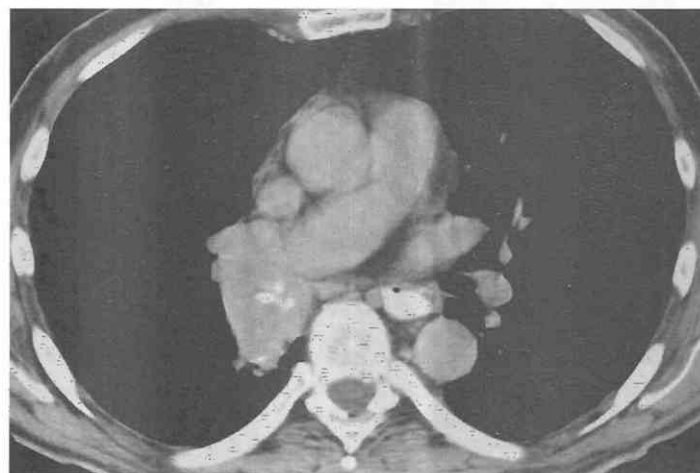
Atypical carcinoid tumor with rib and hepatic metastases at presentation. CT shows a large endobronchial mass with dense punctate calcification.
